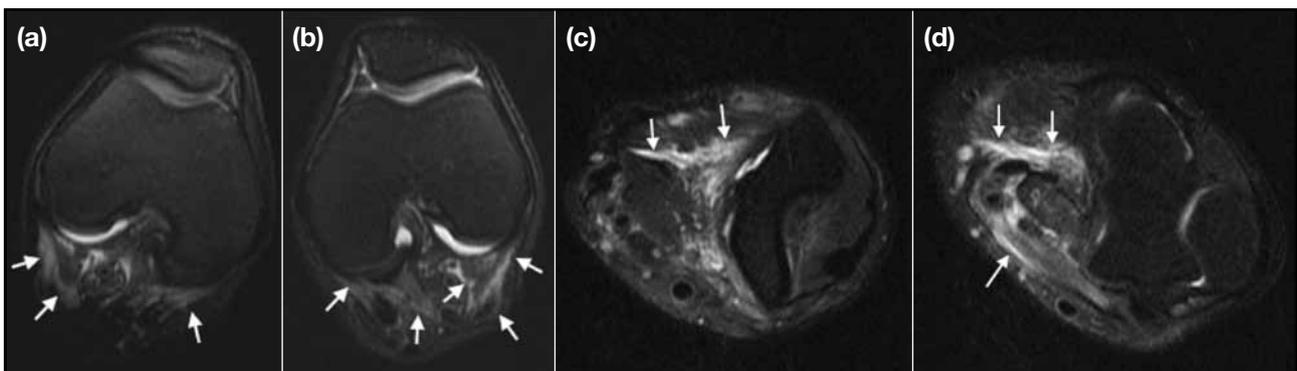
Fat-suppressed T2-weighted magnetic resonance imaging of the (a) right and (b) left knees and (c) and (d) left elbow in axial plane showing a thin rim of fluid along the fascia planes (white arrows) with fascia thickening in the knees and elbows. Symmetrical findings are noted in the right elbow (not shown).
